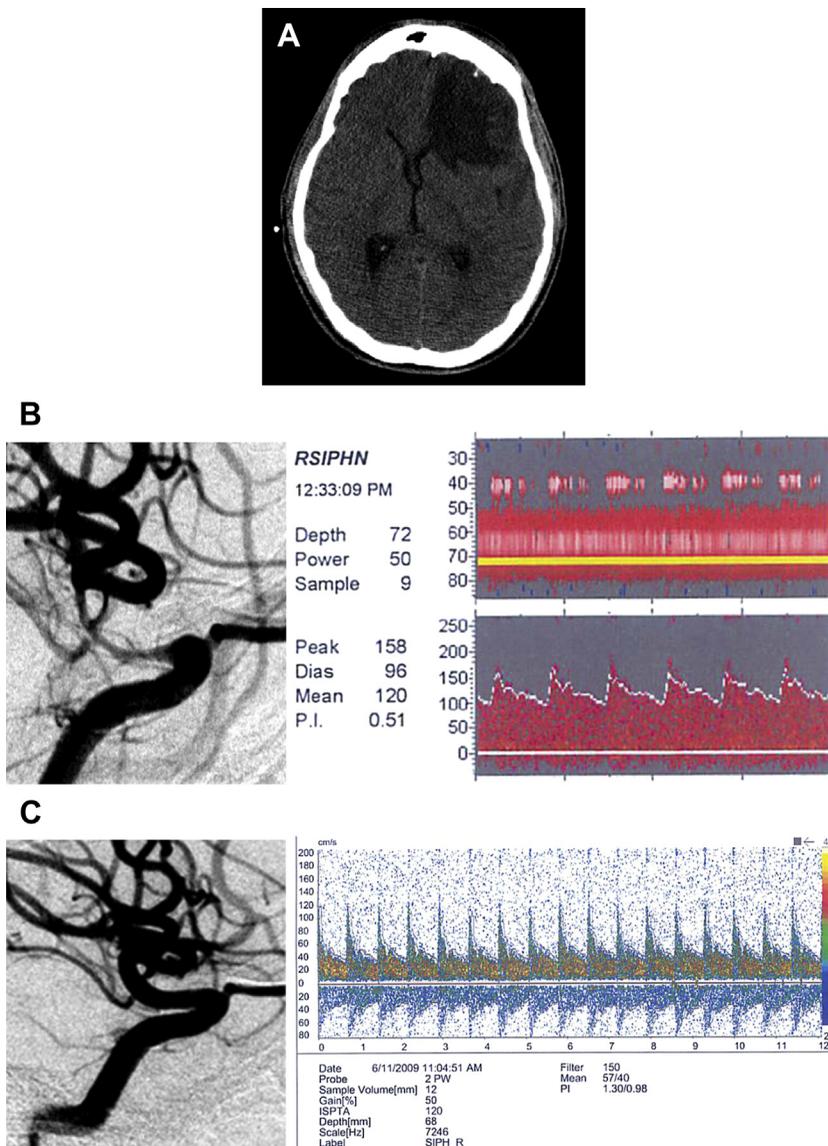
Patient with right side contusion, base skull Fx, L1-L5-Fx. (A) CT scan demonstrating contusion. (B) Right common carotid artery injection showing severe vasospasm affecting right carotid siphon before angioplasty and corresponding TCD measured CBFV in the right carotid siphon. (C) Resolution of vasospasm after transluminal angioplasty and TCD showed CBFV normalization after angioplasty.
